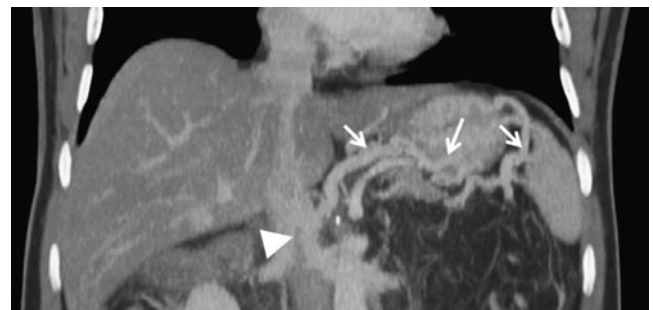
Patient 3. Coronal MIP postcontrast computed tomography. Large veins from splenic hilum connect to a network of smaller veins around and in the stomach. These led to other large veins on the other side of the stomach, which united to form the coronary vein, which terminated in the portal vein (arrowhead)
